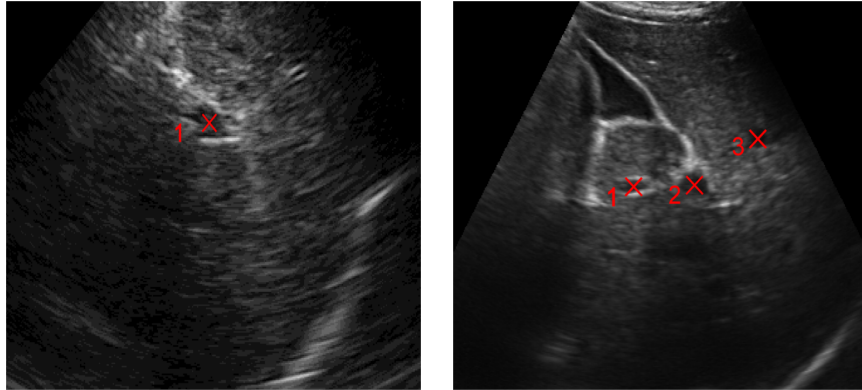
Sample reference ultrasound images and landmarks from the liver ultrasound tracking challenge CLUST 2015.
